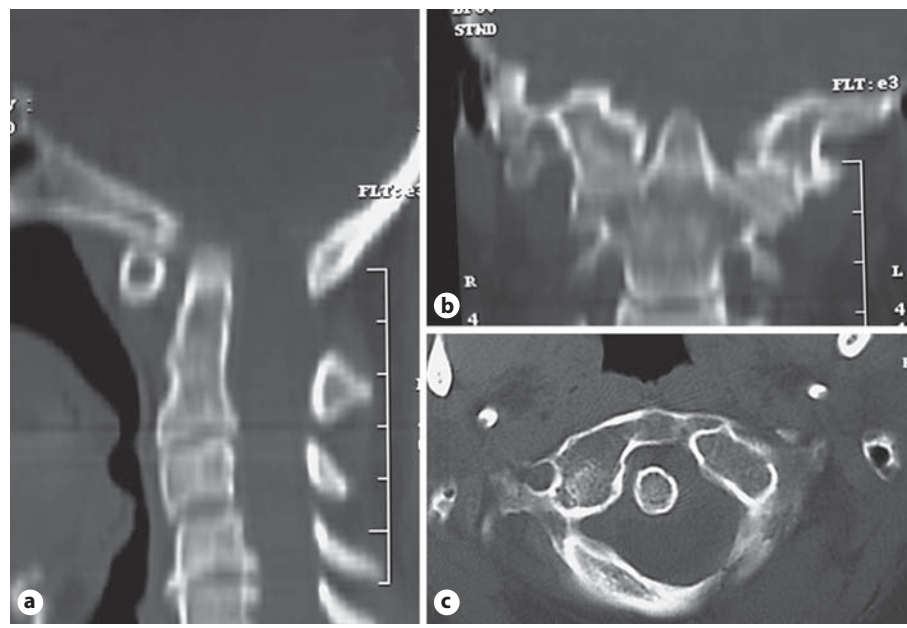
a Preoperative sagittal CT scan demonstrating assimilation of the C₁ arch into the occiput and basilar invagination. b Preoperative coronal CT scan demonstrating eccentric location of the odontoid. c Preoperative axial CT scan demonstrating eccentric location of the odontoid.
